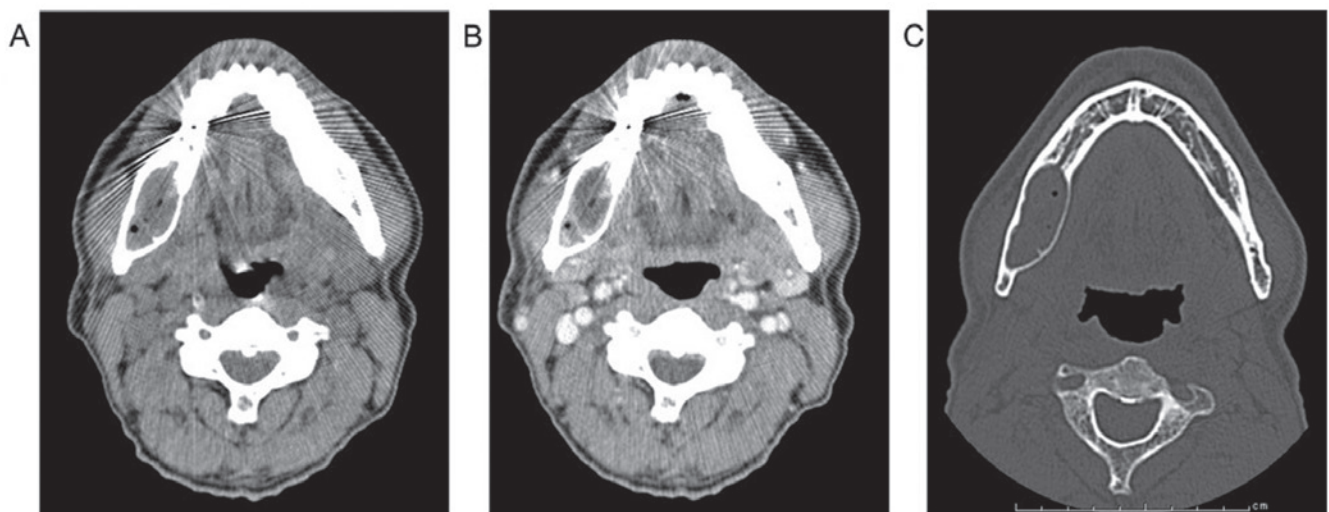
CT images of mandibular lesion. (A) Axial soft tissue CT images show multilocular lesion with clear boundary, low and several low concentration areas, which seems mixed with air, (B) axial contrast-enhancement demonstrated heterogeneous area inside the lesion, and (C) axial bone CT image showing bone was bulging on the lingual side.
